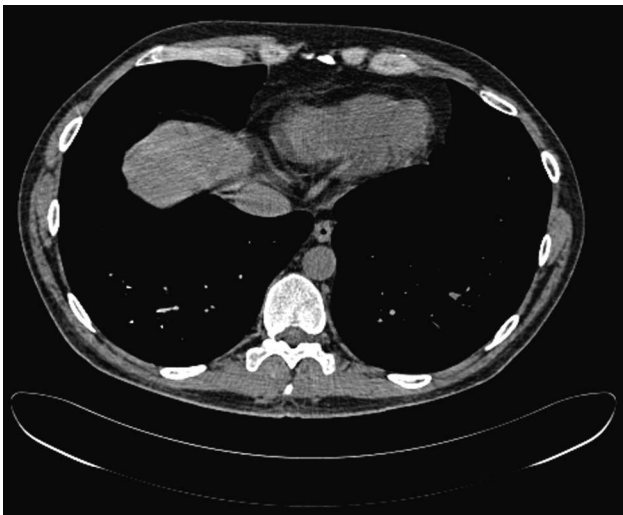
Mediastinal window computed tomography together with the pulmonary micronodules.
